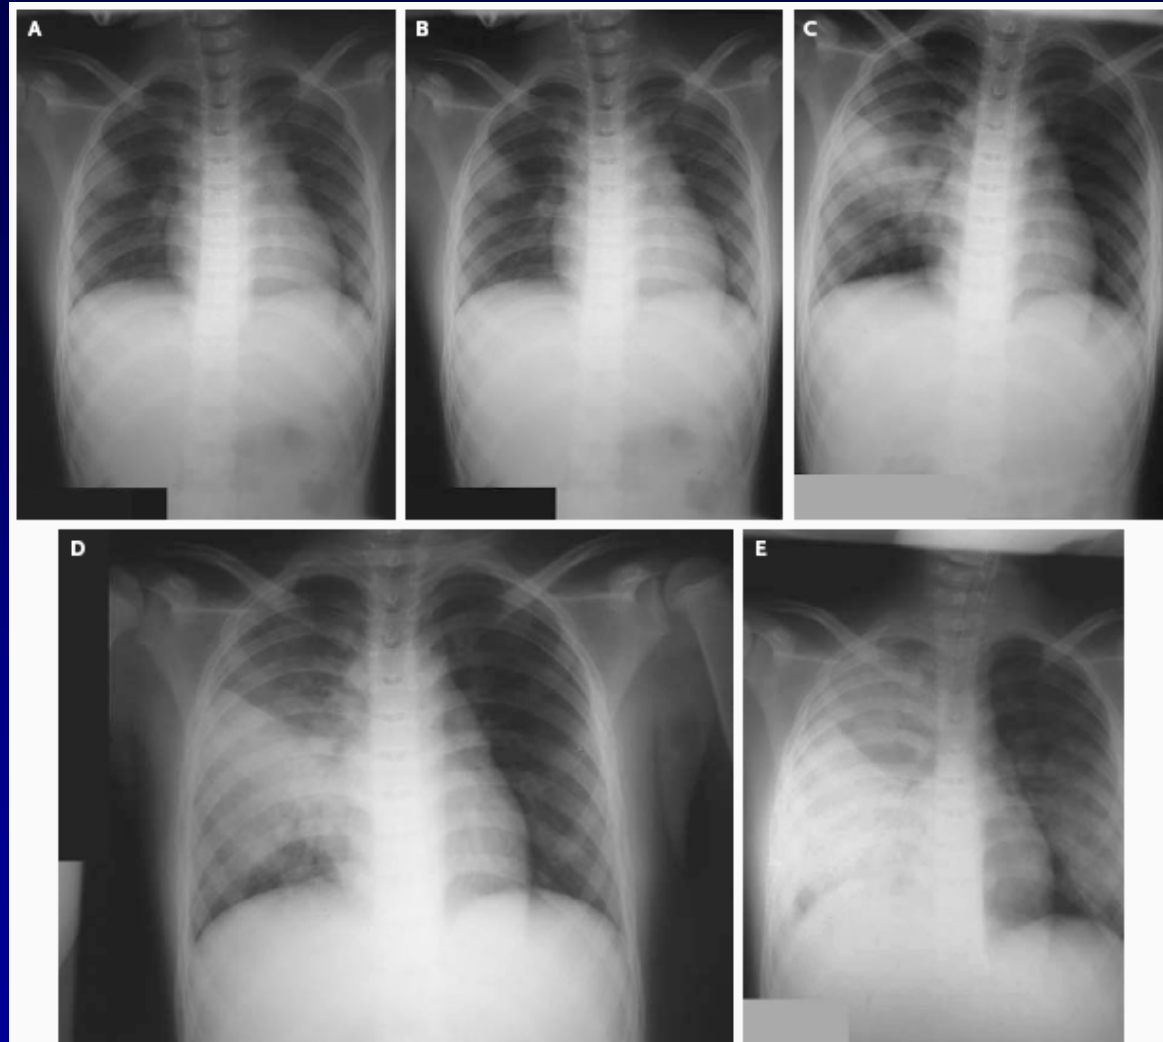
Serial Chest Radiographs Obtained from Patient 1.
